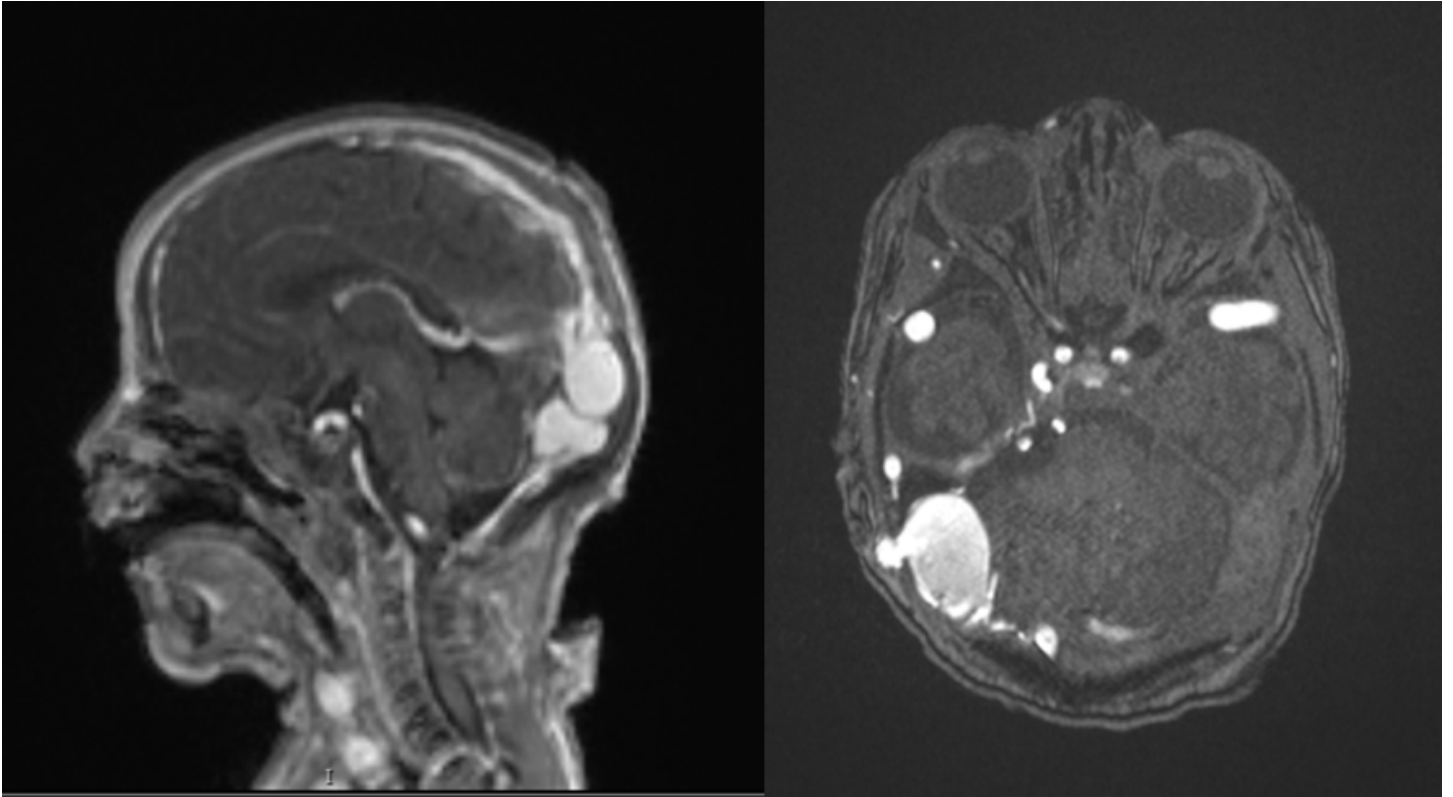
MRI shows a large predominantly right-sided posterior fossa dural arteriovenous malformation.
